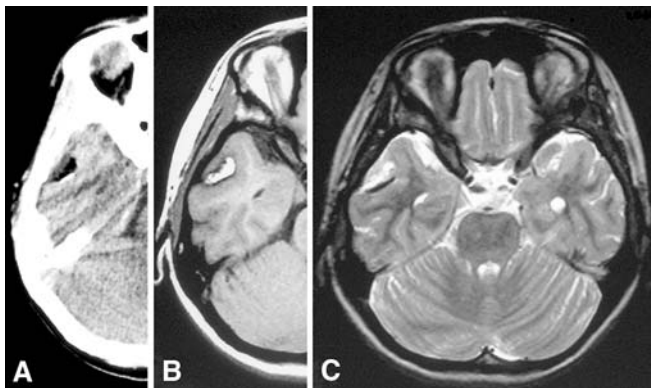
Preoperative neuroimaging of the lesion. A An image from a noncontrast CT scan through the right half of the head shows a low-density mass at the anterolateral portion of the temporal lobe of the cerebrum. The signal is consistent with that of lipid. B, C The lesion exhibits a markedly high signal intensity on axial T1-weighted (B) and T2-weighted (C) magnetic resonance images. A low signal intensity can be seen at the dorsal part of the mass, which corresponds to the high-density area on the CT scan (A). This indicates the presence of calcification. Note that no surrounding edema or mass effect is present (CT computed tomography)
